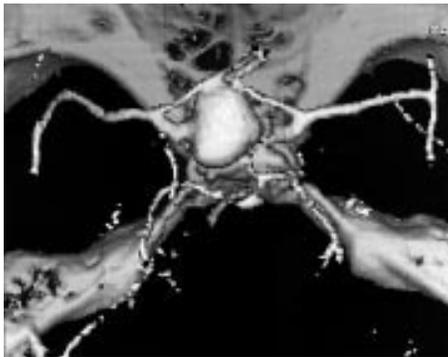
Three dimensional computed tomographic angiography of an anterior communicating aneurysm.
